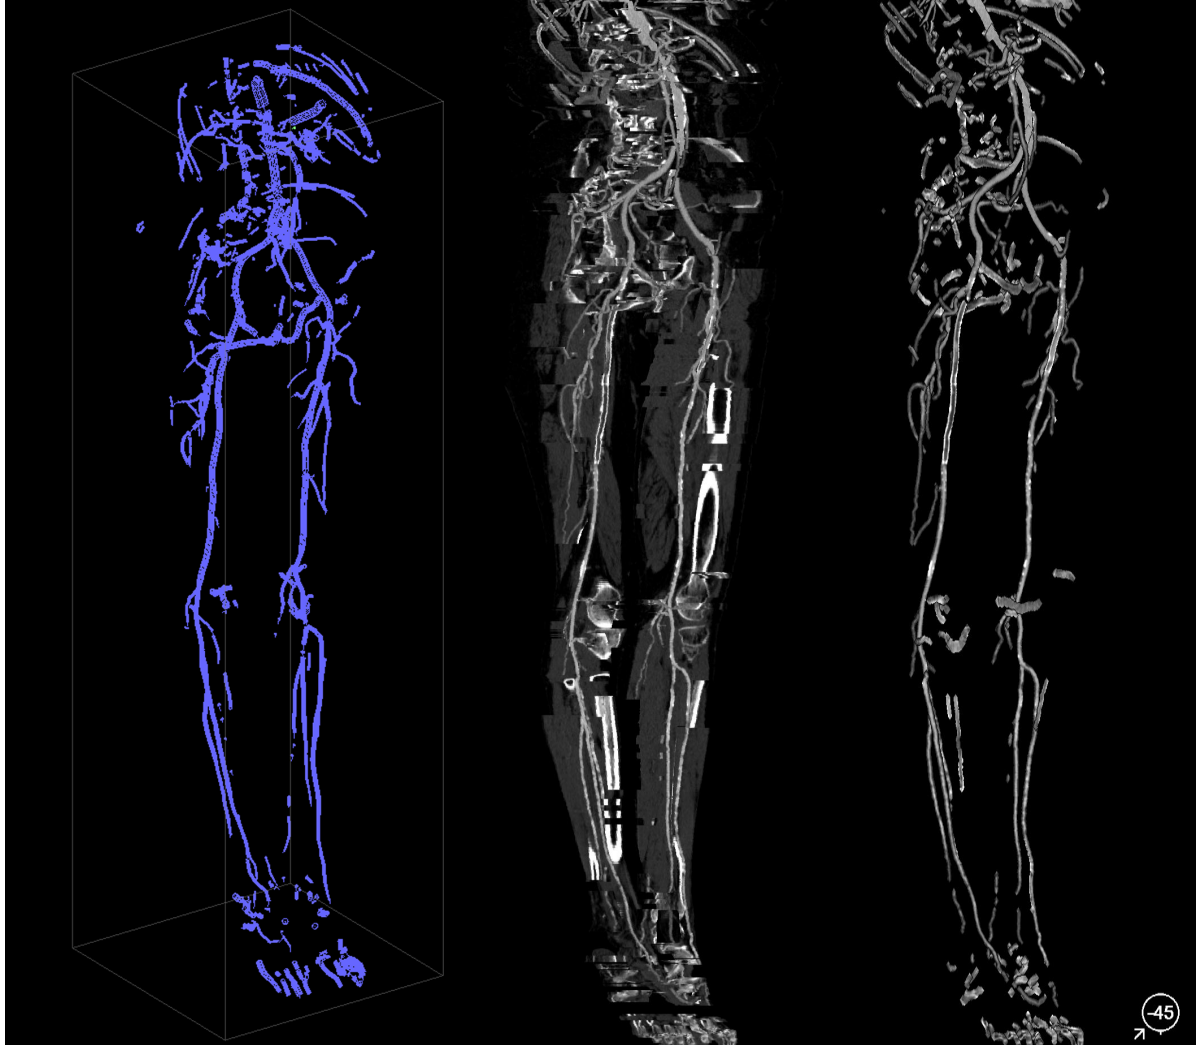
Comparison of mpCPR and CR of the peripheral arteries of a human data-set, acquired by CTA. The left image shows a perspective projection of the vessel tree using a cylindrical model, supported by the AVT, for visualization. The thickness of the vessels corresponds to the size of the cylinders. The middle and right image use orthogonal projection. The middle image shows the mpCPR of the vessel tree. Since the tree is very branched, the image will be highly partitioned. The right image displays the vessel tree using CR. Due to the different sampling approach, no surroundings are created, leading to a clearer visualization of the structure of the vessel tree. (Images created using the AngioVis Toolbox)*
